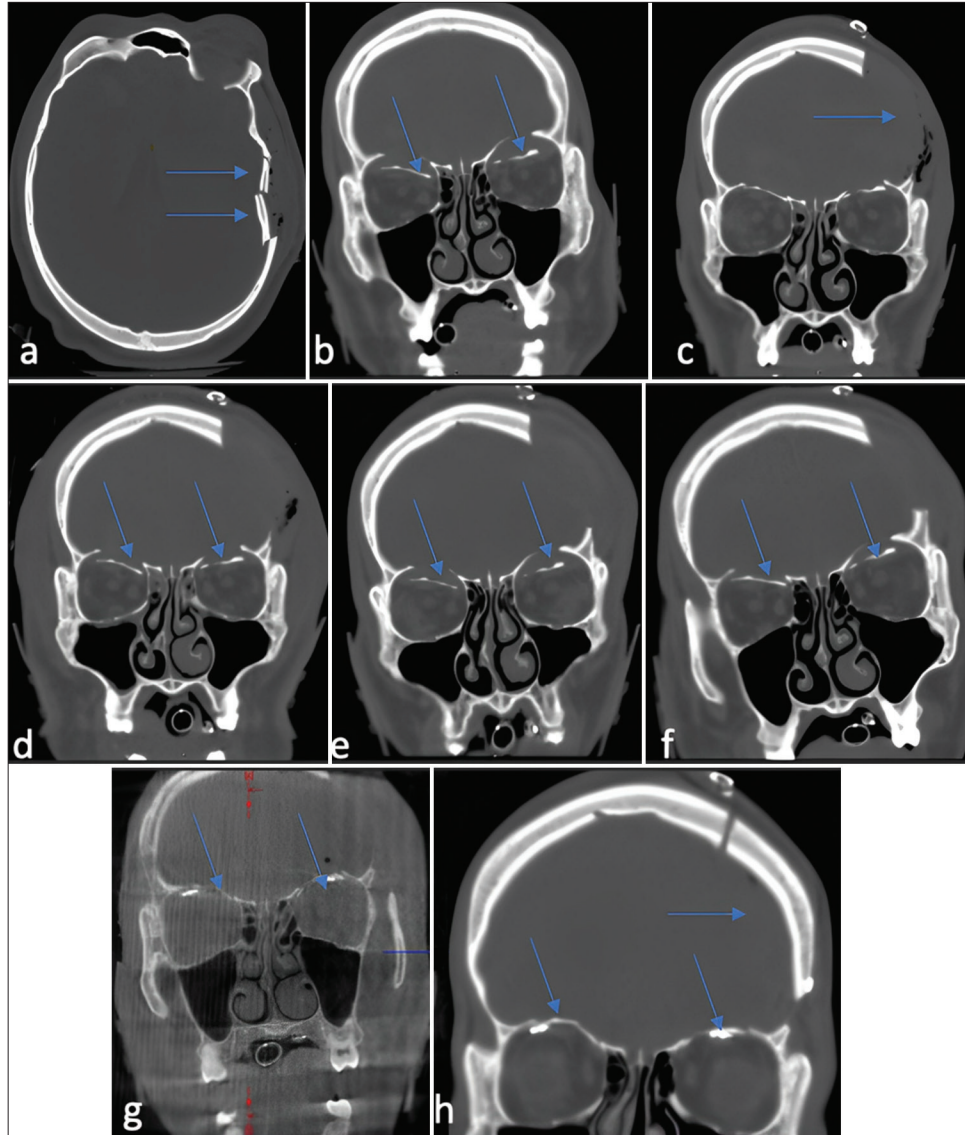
(a and b) Case 1: Computed tomography (CT) imaging of fracture fragments over time. Axial and coronal bone window CT images from admission demonstrating left calvarial depressed skull fracture fragments and bilateral orbital roof blow in fractures. (c) Coronal CT bone window status post left-sided decompressive craniectomy on postoperative day 0. (d-f) Migration of fragments over time shows 3 mm and 2.9 mm of inferior displacement on the right and left side, respectively. (g) Intraoperative O-arm CT after orbital roof reduction and fixation and (h) post cranioplasty 1 month after orbital roof repairs. *Arrows denote findings described in each image.
